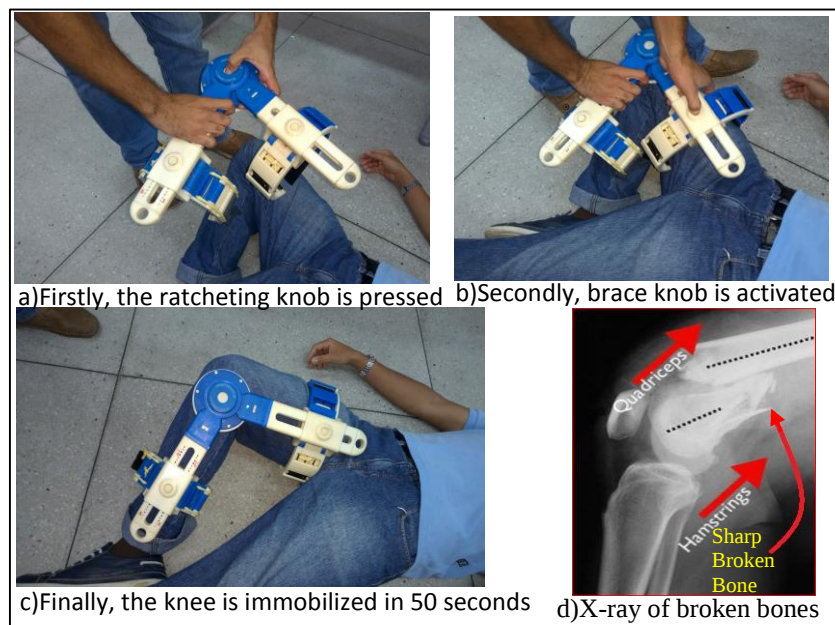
The performance of the knee immobilization equipment and an X-ray of a broken bone.
